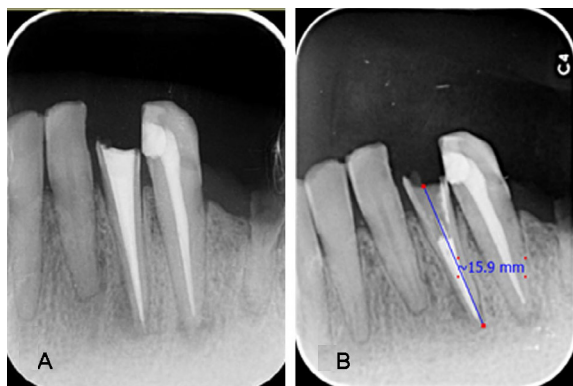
(A) Initial radiograph showing flared root canal space with thin dentinal walls. (B) Radiographic view at the stage of gutta-percha removal. Note the extremely thin dentinal wall in the mid-mesial portion of the root (approximately 0.3mm)
